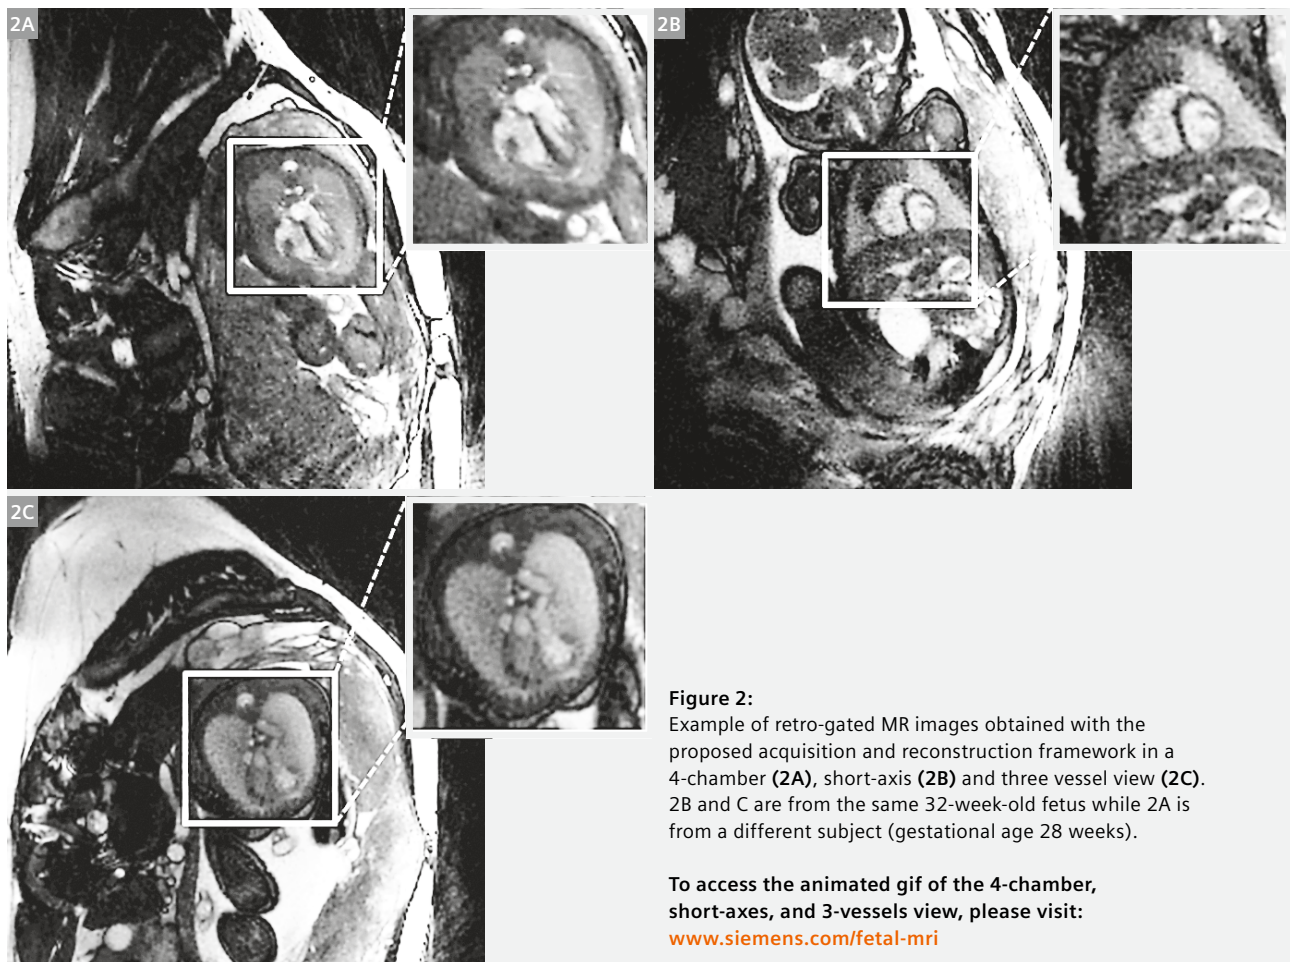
Example of retro-gated MR images obtained with the proposed acquisition and reconstruction framework in a 4-chamber (2A), short-axis (2B) and three vessel view (2C). 2B and C are from the same 32-week-old fetus while 2A is from a different subject (gestational age 28 weeks).
